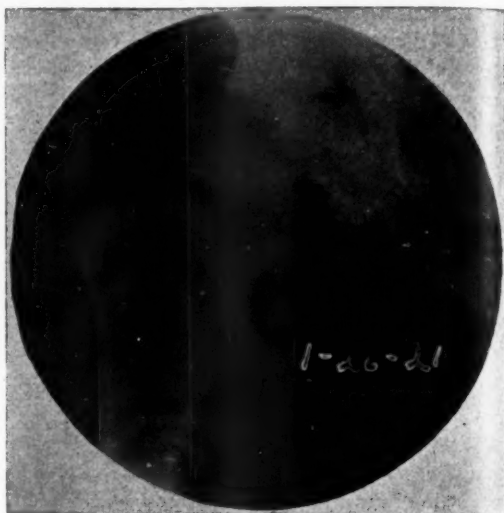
(Case 3). Roentgenogram showing impacted fracture of neck of femur.
